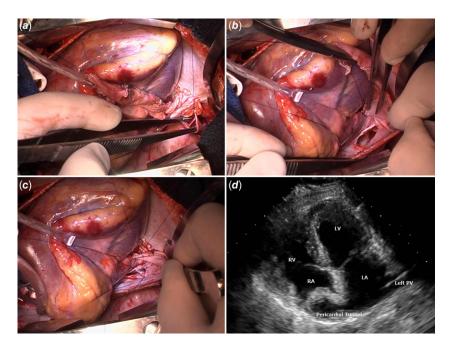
(a) The proximal end of the Scimitar vein was rotated toward the pericardial "well" to identify the site of anastomosis. (b) A 2 cm elliptic portion of the pericardium was excised. (c) a termino-lateral anastomosis of the Scimitar Vein was performed. (d) Post-operative transthoracic echocardiography demonstrating a wide channel towards the left atrium
